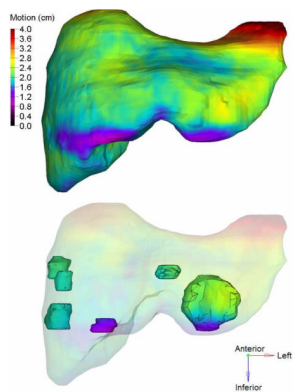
Example of an exhale liver (top), and intrahepatic GTVs (bottom). The 3D motion map overlaid is found by deforming the exhale to inhale CT. Regions of the liver move 4 cm in this case, due to breathing induced deformation.
